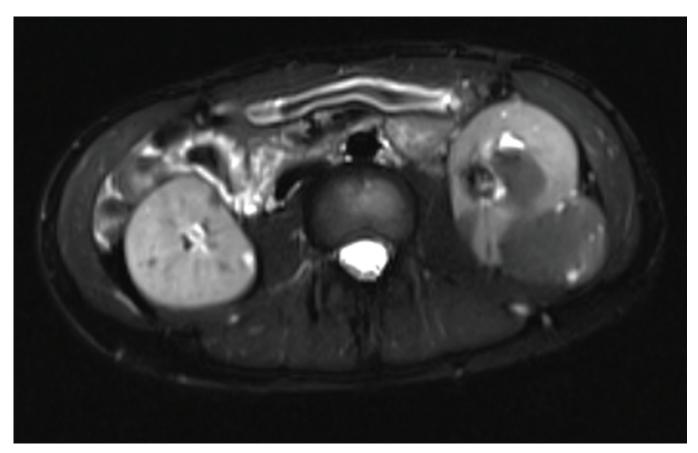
Exophytic fat-poor (atypical) AML in the left kidney of a TSC child (MRI)
